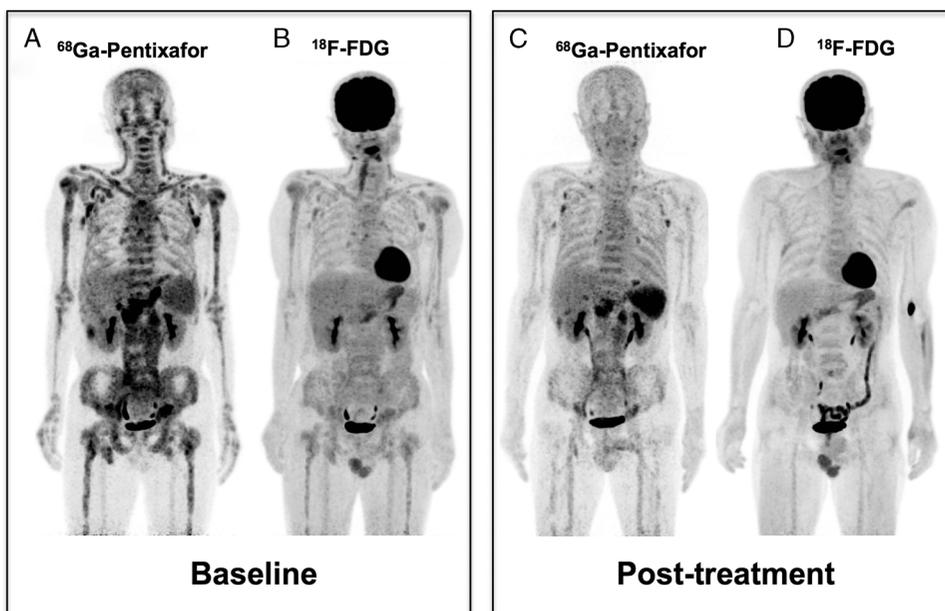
Patient 9 (male, 58 years, intermediate risk of ISS-WM) with clinical PR after 5 cycles of chemotherapy with rituximab and lenalidomide. At baseline, ^{68}Ga -pentixafor PET/CT (A) showed involvement in bone marrow, paramedullary disease, lymph nodes, liver, and pancreas; meanwhile ^{18}F -FDG PET/CT (B) missed most of the extramedullary disease, and only revealed moderately increased uptake in bone marrow involvement. Nine months after completion of chemotherapy, ^{68}Ga -pentixafor PET/CT (C) showed remarkable reduced uptake in bone marrow and PR of the extramedullary disease. The follow-up ^{18}F -FDG PET/CT (D) also revealed some reduction in bone marrow uptake and PR in some lymph nodes.
